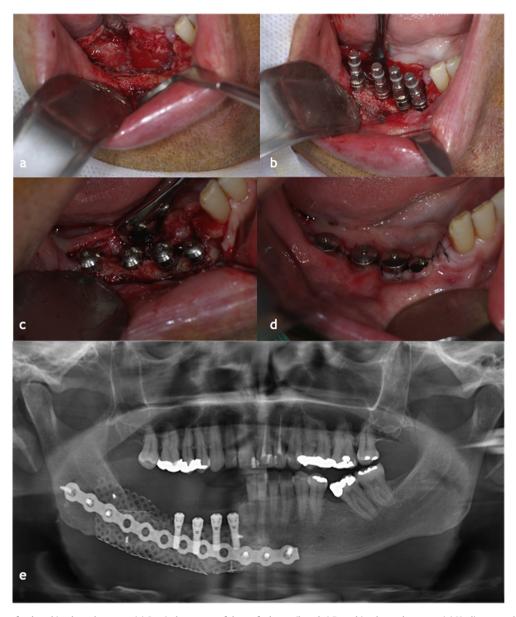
Surgical procedure for dental implant placement. (a) Surgical exposure of the grafted area. (b and c) Dental implants placement. (e) Healing caps placement. (f) Panoramic radiograph of dental implants in position.
